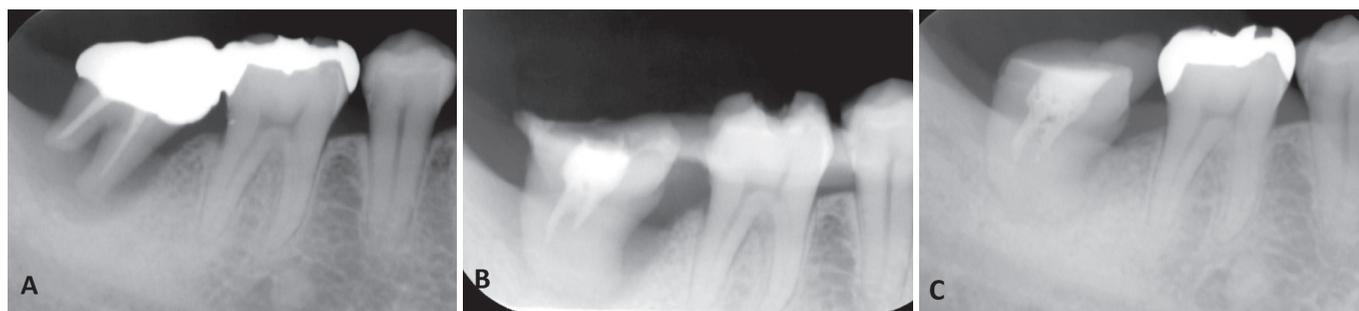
A) Pretreatment conventional intraoral radiograph of the right mandibular second molar. B) Conventional intraoral radiograph taken 1 week after autotransplantation. C) Conventional intraoral radiograph taken 15 months after the operation, showing regeneration of alveolar bone around the involved root.
